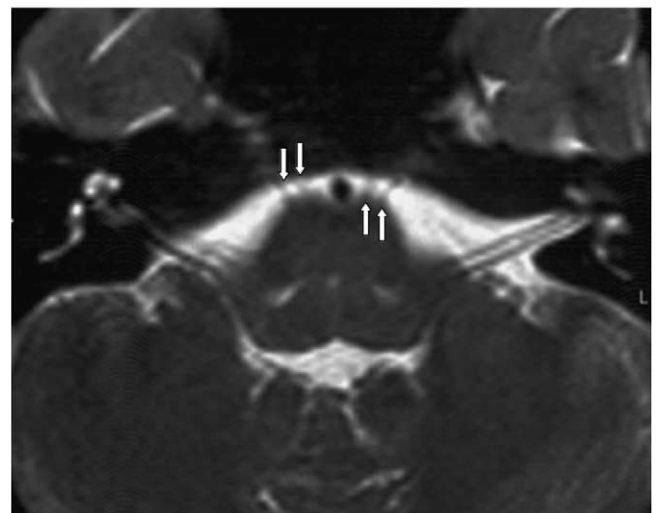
MR images obtained in the axial plane by using a 3DT2-TSE sequence. (A) Serial axial 3DT2-TSE images at the level of cisternal segment of the abducens nerve (arrows) shows the entire nerve between the brainstem and epidural part of the abducens nerve. (B) Epidural part of the abducens nerve (arrows) can be identified as a CSF filled evagination.
